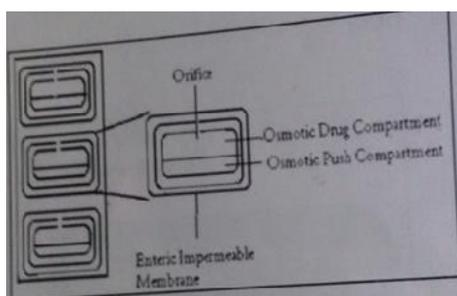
10 OROS-CT (REFERENCE:57)
